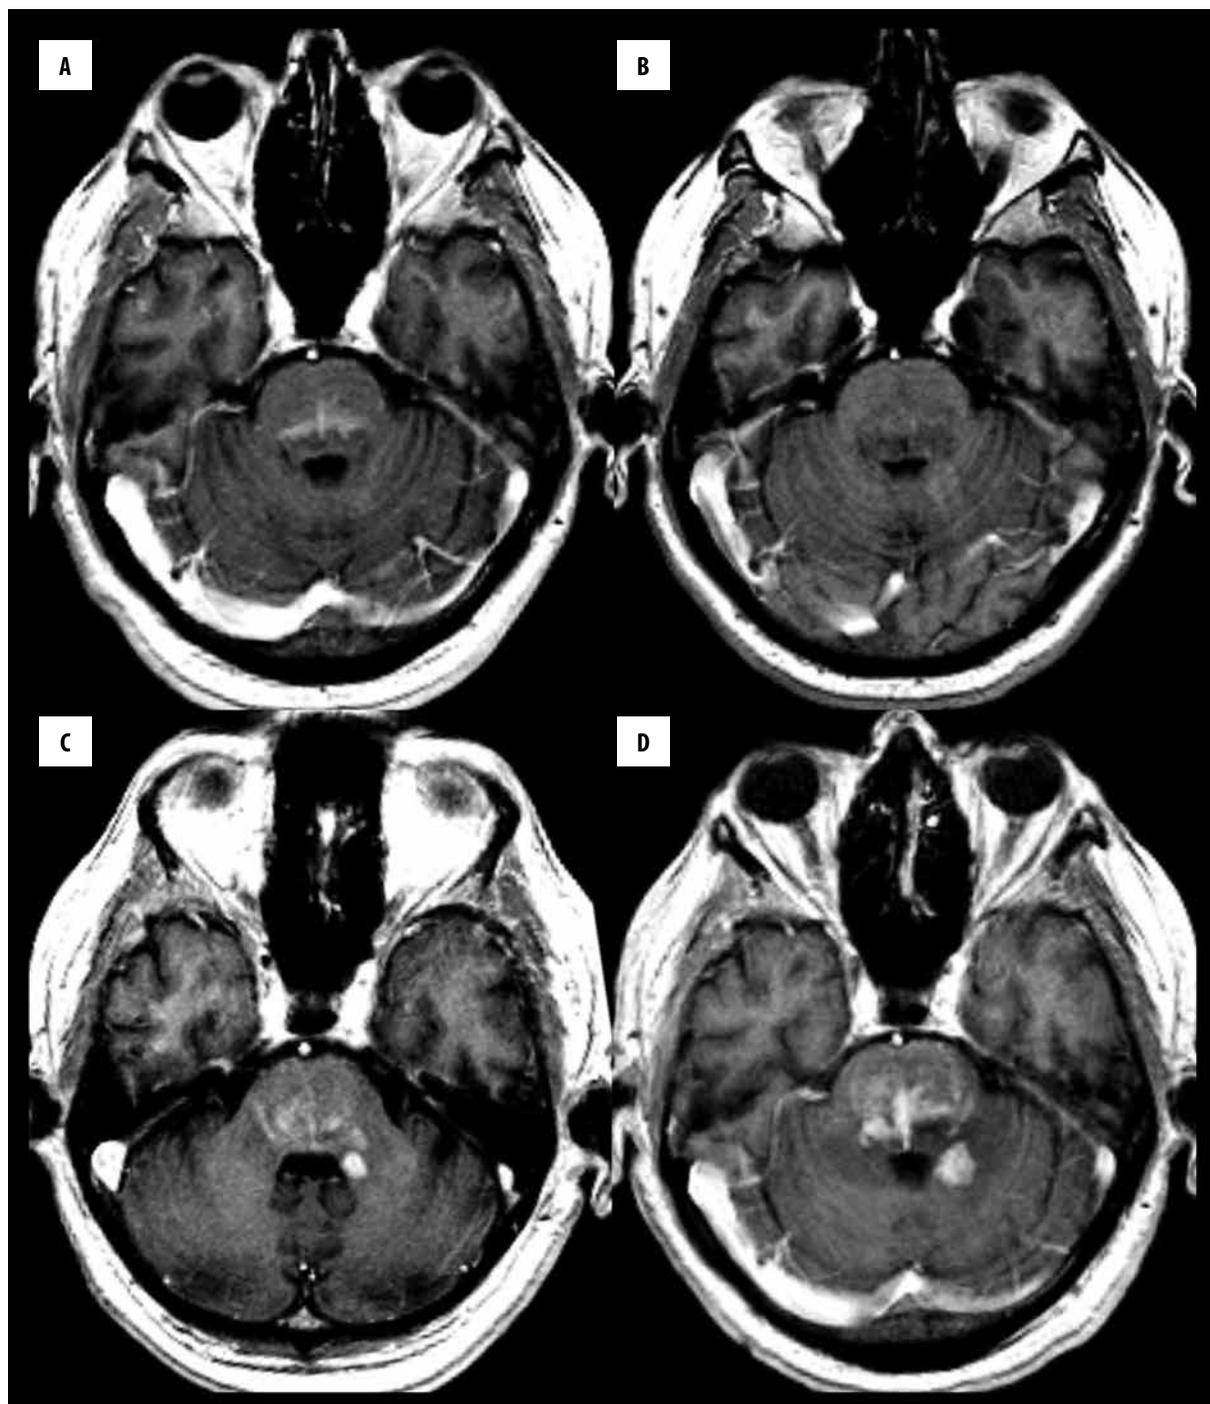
Following MRI in a patient with Bickerstaff encephalitis; T1-weighted images after contrast enhancement. In initial MRI, a small central area slightly enhancing after injection of the contrast medium (A). Regression of changes in the brainstem and no significant enhancement lesion in MRI after 5 months (B). MRI after 1.5 year revealed irregular areas of enhancement after injection of the contrast medium (C). An intensive, irregular area with strong enhancement after injection of the contrast in a subsequent MRI (D).
